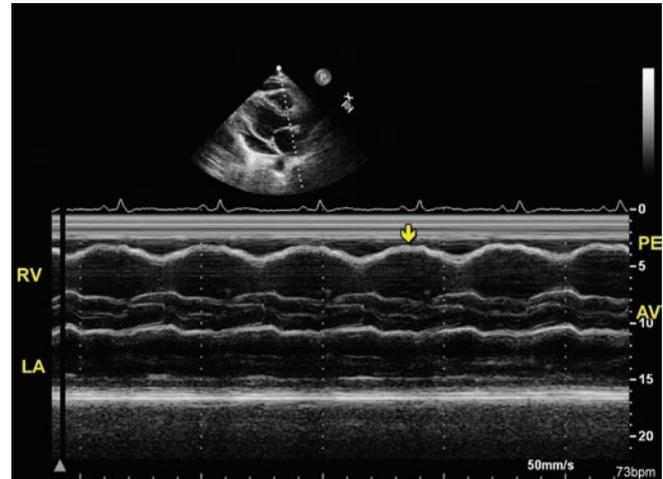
M-mode echocardiogram showing flattening of RV wall with atrial systole (arrow) but there is no downward motion.
